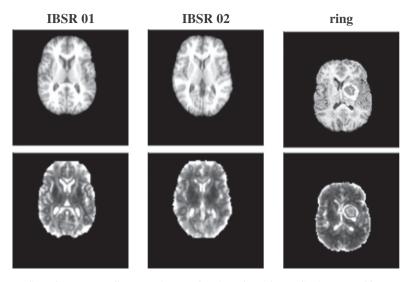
Some images and their corresponding saliency maps. All computations are done in 3D but only one slice is presented here. Parts of the brain MRI presenting a high contrast (like the lateral ventricles, dark structures in the center) present high saliency values in the corresponding image. The tumor in the example on the right also presents high saliency values.
